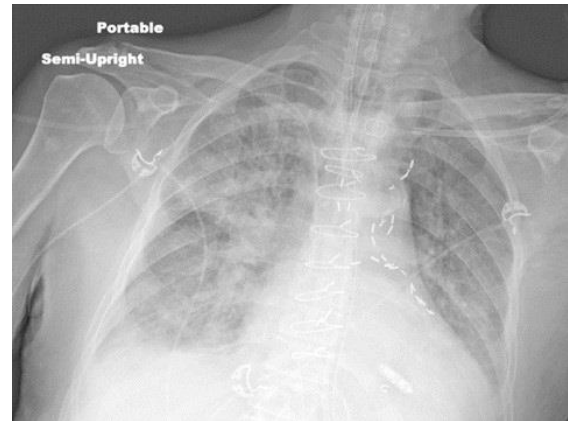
Repeat portable chest x-ray taken after 10 days of mechanical ventilation just prior to extubation.
